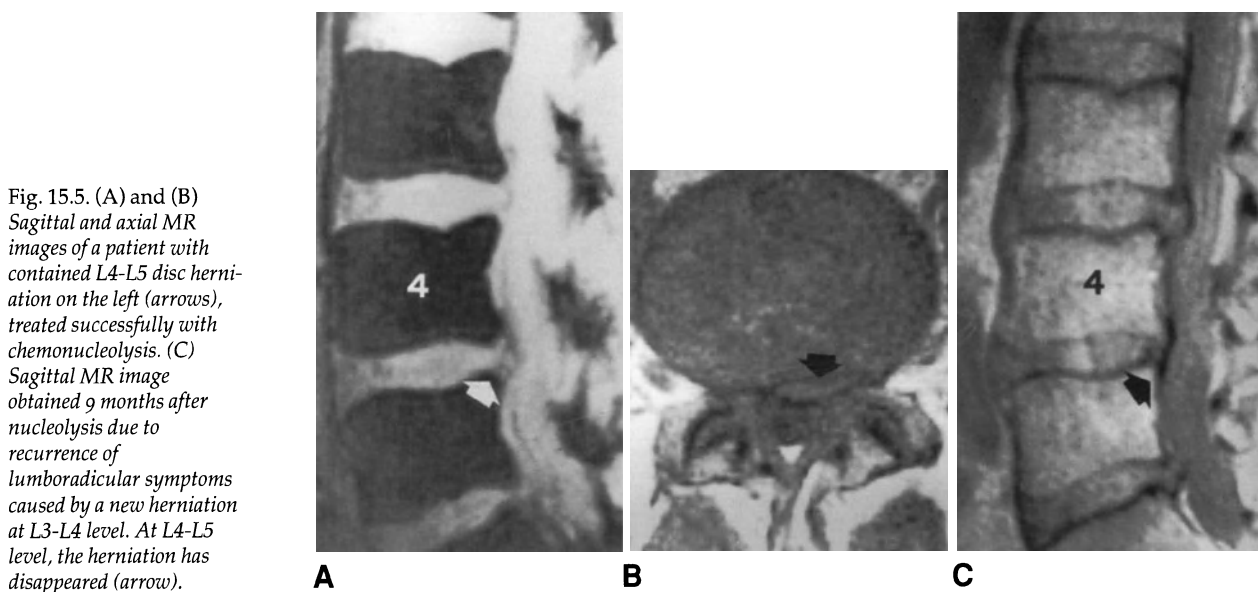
(A) and (B) Sagittal and axial MR images of a patient with contained L4-L5 disc herniation on the left (arrows), treated successfully with chemonucleolysis. (C) Sagittal MR image obtained 9 months after nucleolysis due to recurrence of lumboradicular symptoms caused by a new herniation at L3-L4 level. At L4-L5 level, the herniation has disappeared (arrow).
